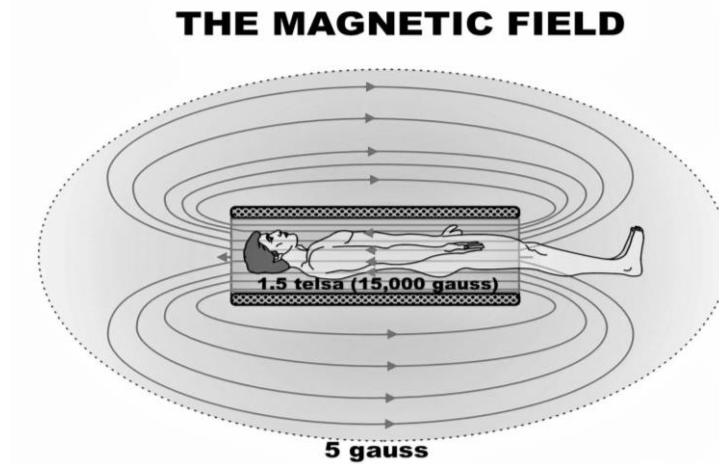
Visual representation of how the magnetic field forms within the MRI [21]
